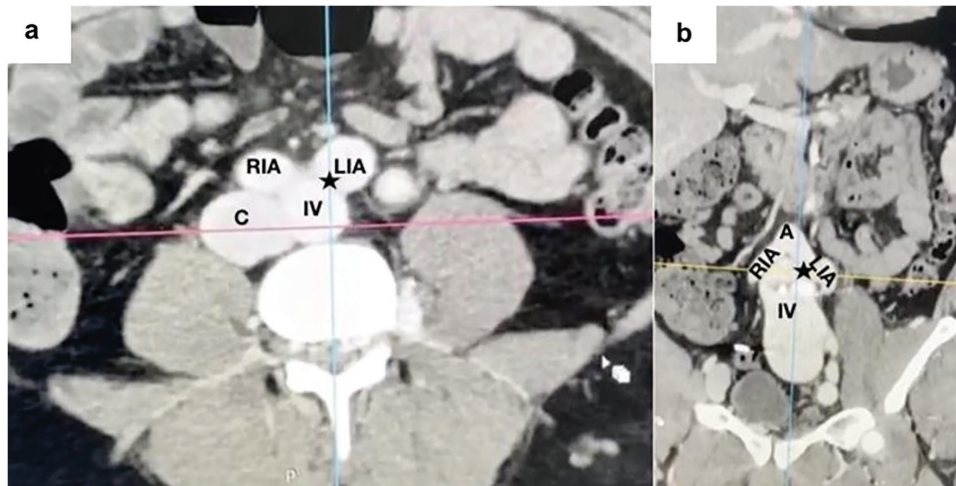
Abdominal computed tomography with intravenous contrast. (a) Axial view; RIA: right iliac artery; LIA: left iliac artery; IV: left iliac vein; ★: arteriovenous fistula (AVF) between the left common iliac vessels; C: inferior vena cava. (b) Coronal view. Note the large saccular dilation of the left common iliac vein.
